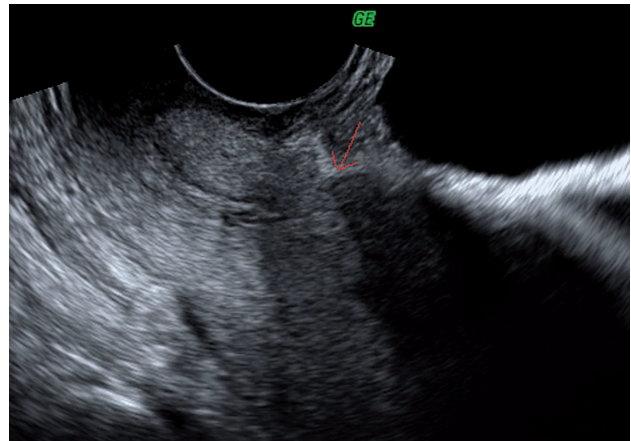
Ultrasonographic appearance one week from operation.
